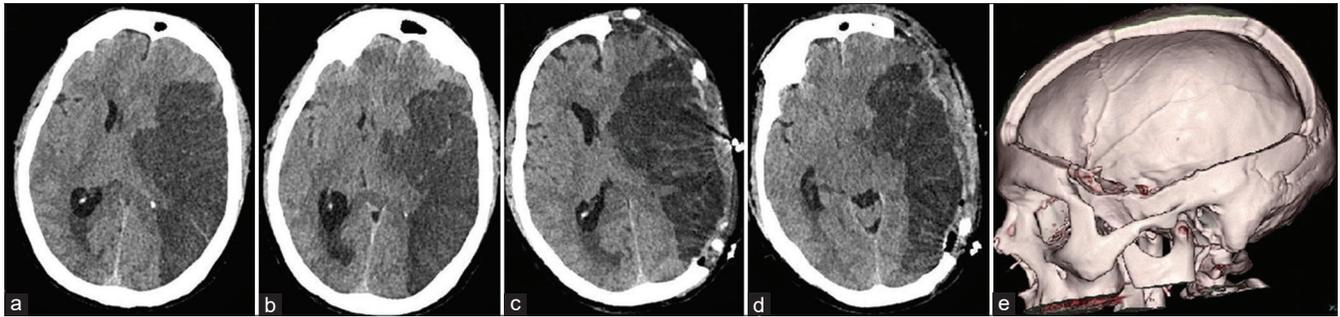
Axial CT images preoperatively (a and b) showing a large left MCA territory infarct with mass effect and midline shift. Postoperative axial CT images on the 1st postoperative day (c and d) showing adequate AP bone removal and opening up of the ventricles and cisterns. A 3D reconstruction (e) of the large DC that was achieved by the n-shaped incision is also shown. CT: Computed tomography, MCA: Middle cerebral artery, AP: Anteroposterior, DC: Decompressive craniectomy
